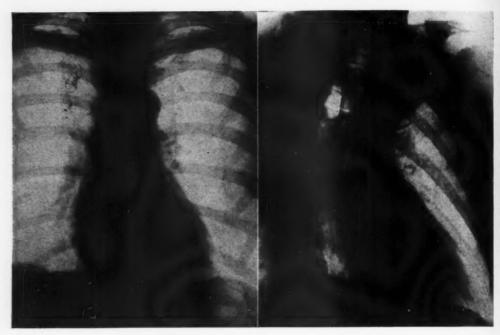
and 2b (169402). Roentgenograms of a rta in first position: (a) anterior-posterior view; (b) oblique view.
